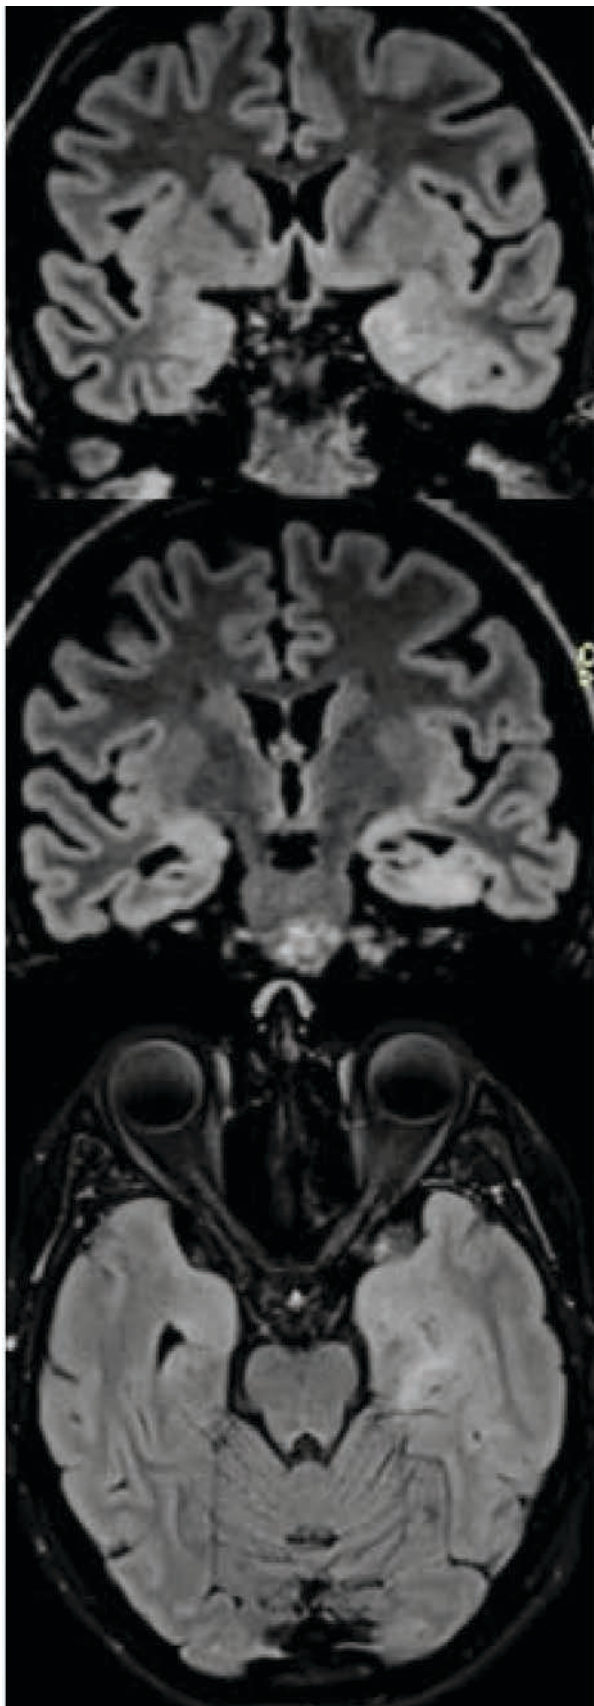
Brain MRI - FLAIR sequences with bilateral temporal hyperintensity left>right
